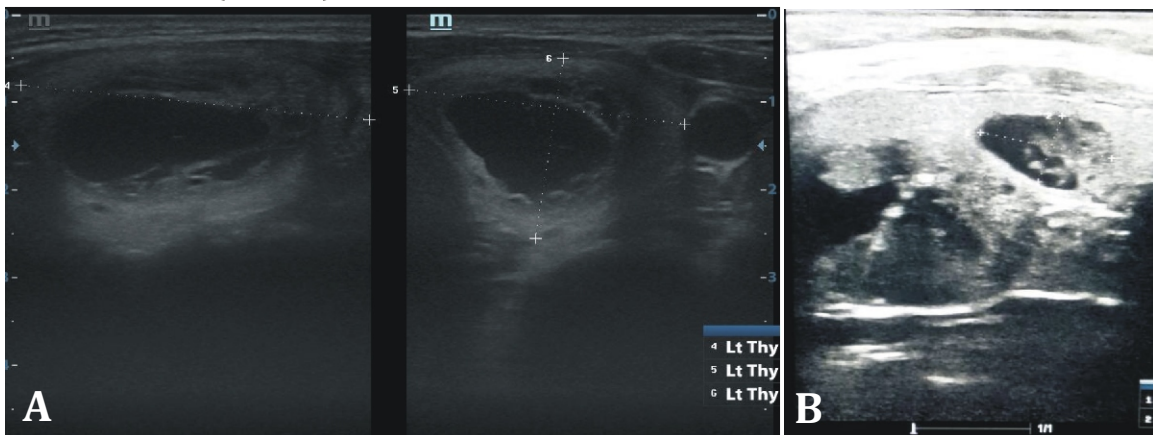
A & B are Gray scale ultrasound images showing thyroid colloid cyst with comet-tail artefacts in A.
